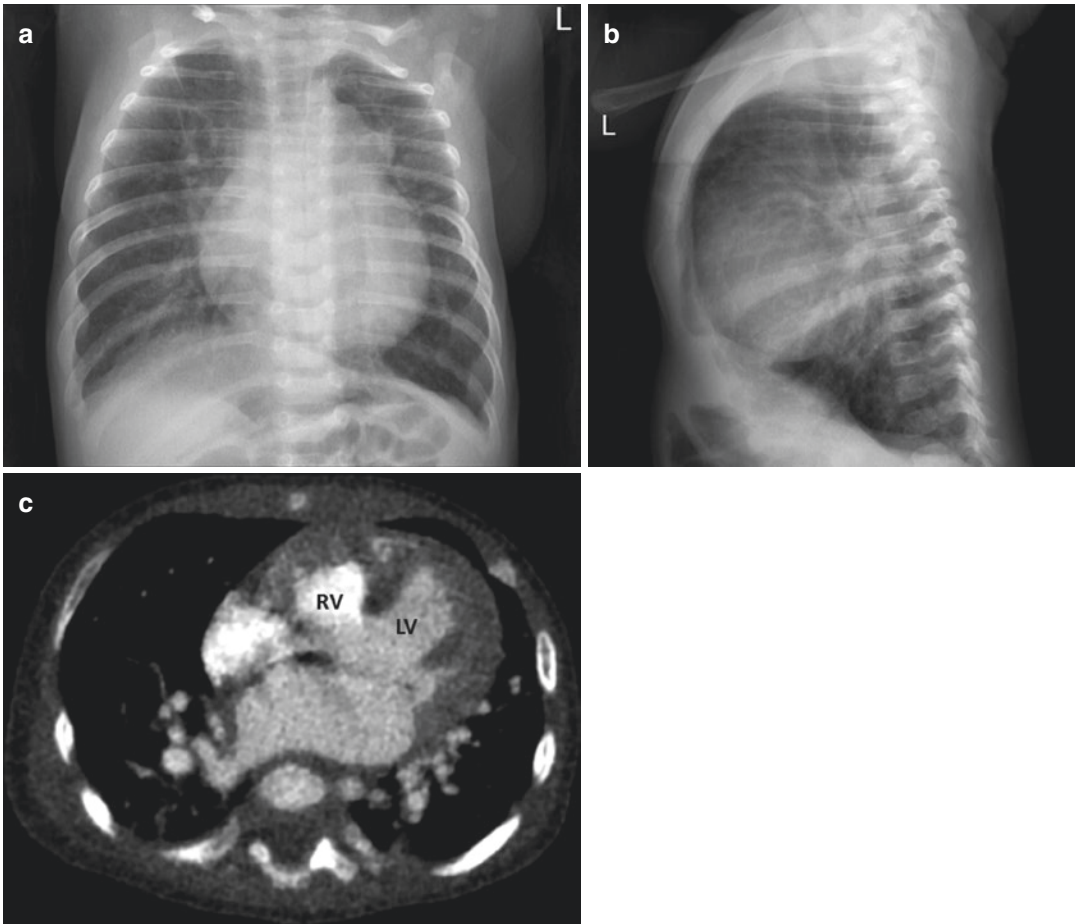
Ventricular septal defect (VSD) in a 4-month-old baby with cardiac murmur for 1 month. (a and b) PA and lateral chest radiographs show increased lung markings, prominent pulmonary arteries and cardiomegaly. (c) Contrast-enhanced CT confirms left atrium and left
